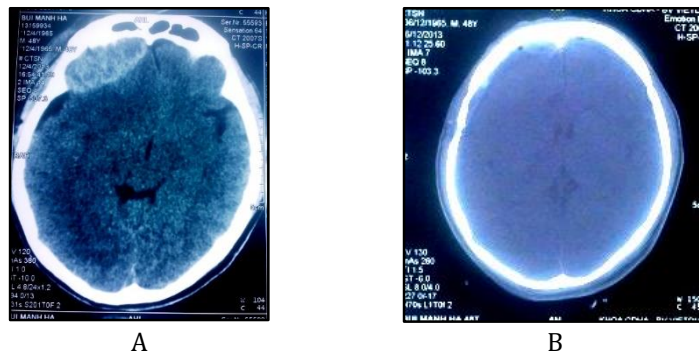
A Preoperative cross-sectional CT scan of traumatic brain injury, demonstrating right frontal epidural hematoma; B. Post-operative cross-sectional CT scan, demonstrating complete resolution of hematoma
